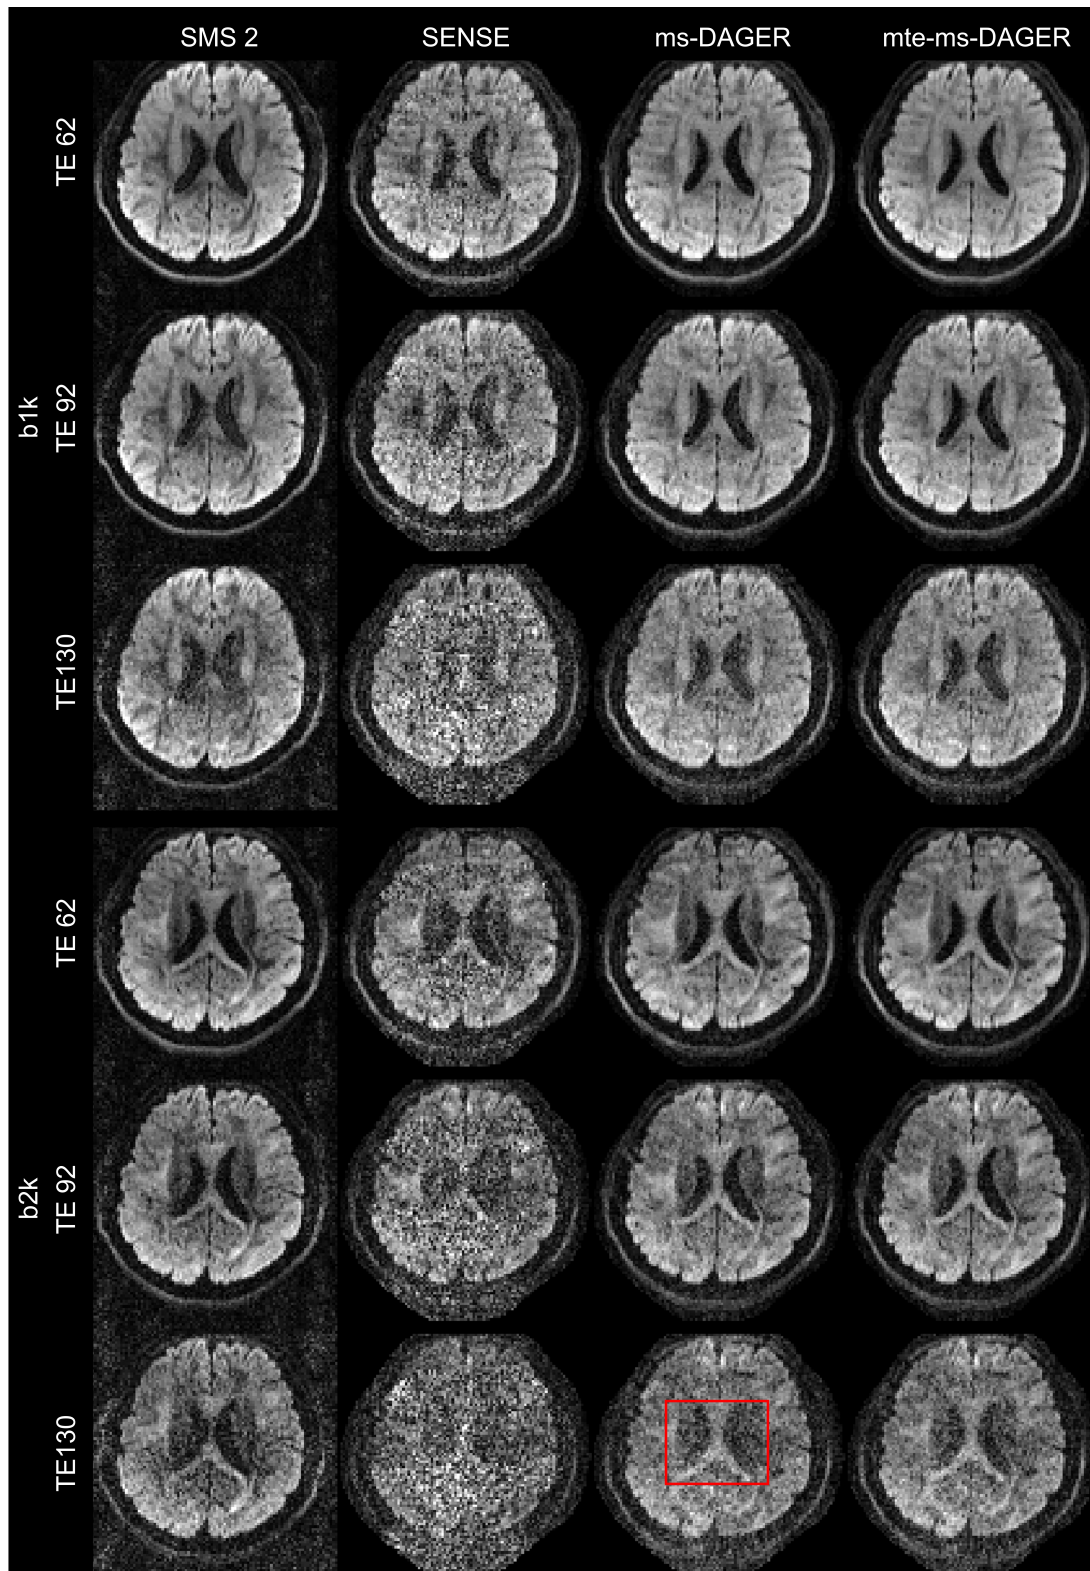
shows the DWI reconstruction results from SENSE and `mte-ms-DAGER` methods for healthy subject 1. SMS = 2 reference data are also shown for  $b = 1000$
